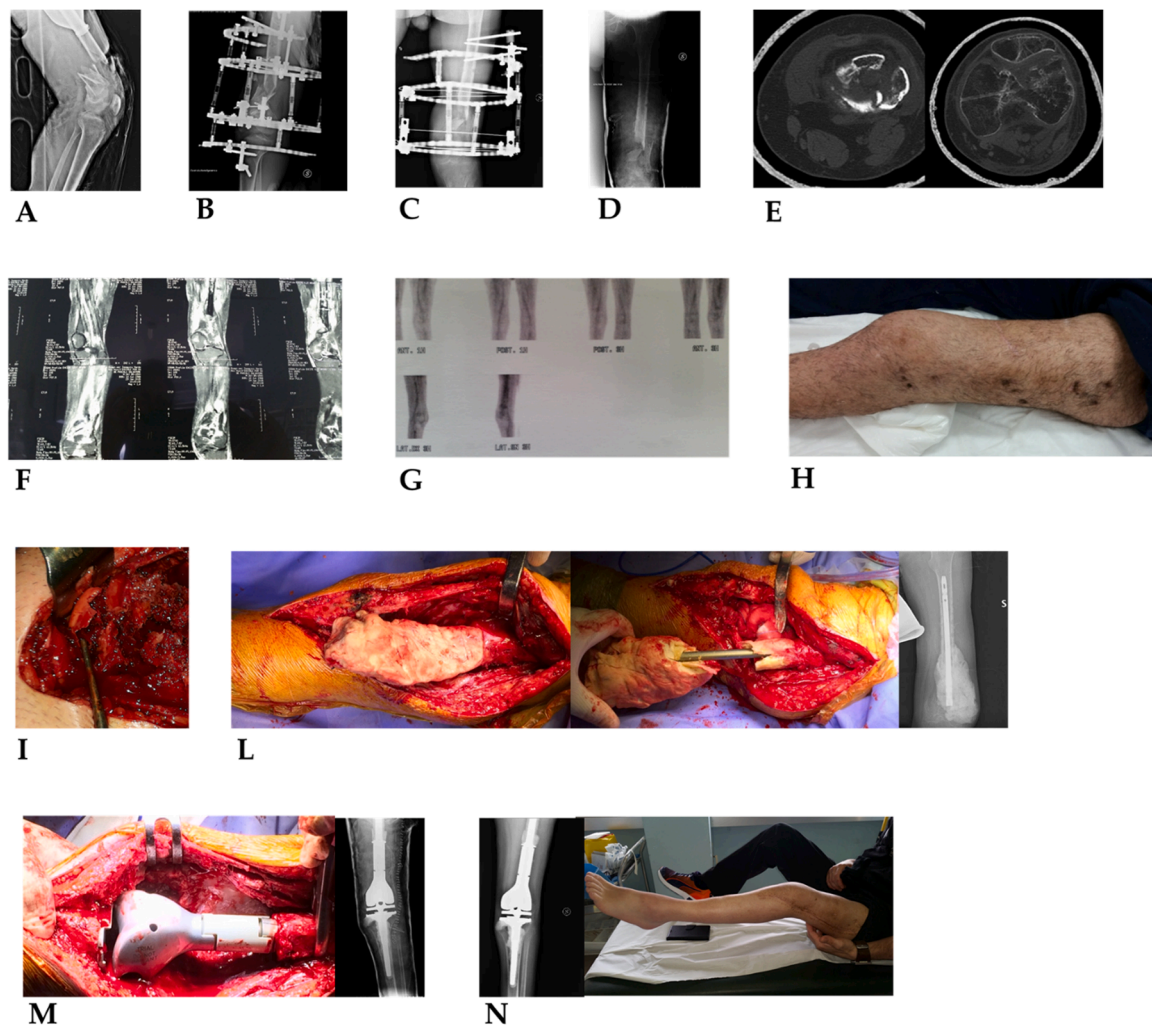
(A): X-ray in the emergency department (ED). (B): X-ray after reduction and stabilization with a circular EF. (C): X-ray after 6 months, showing no evident callus formation. (D): X-ray after removal of the FE. (E): CT scan: osteomalacia. (F): MRI: magnetic resonance imaging. (G): Scintigraphy: positive for bone infection. (H): Clinical examination without fistulas. (I): Severe intra-operative osteomalacia. (L): Pseudotumoral resection and implantation of an antibiotic-loaded spacer with an intramedullary nail core. (M): Implantation of a prosthesis following extensive resection at about 4 months (after antibiotic therapy, HBOT and normalization of inflammatory markers). (N): X-ray and clinical follow-up after 5 months.
